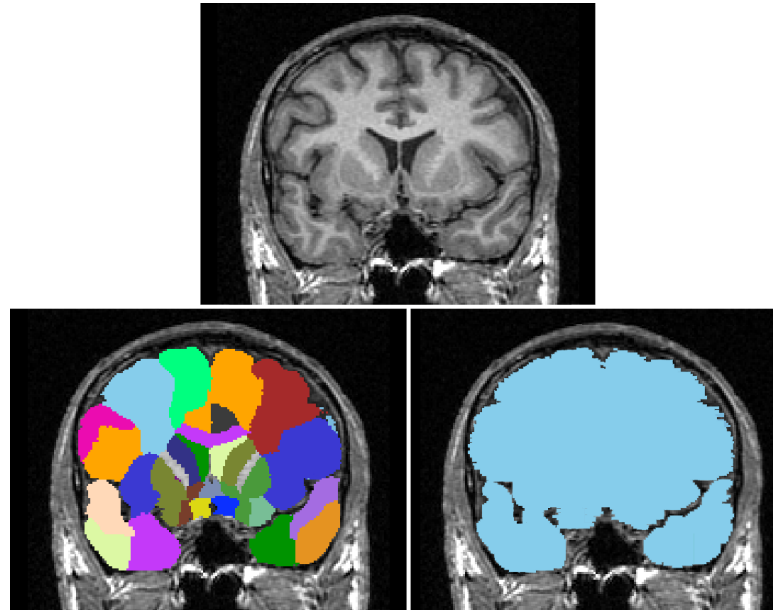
Example of a structural parcellation (bottom left) from the Hammer's Atlas (Hammers et al., 2003) and its corresponding brain extraction (bottom right) overlaid on a T1-weighted image.
